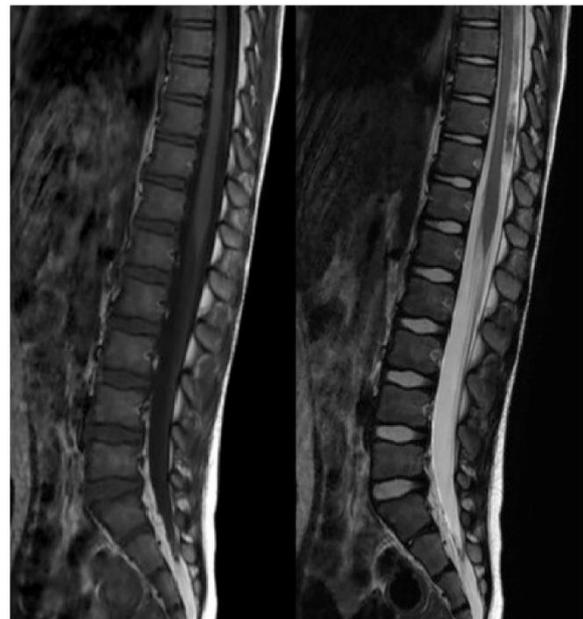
MRI spine revealing thickening of cauda equina.
